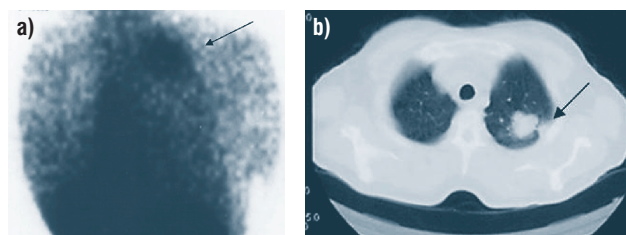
Findings in a patient with squamous cell carcinoma: a) increased uptake of ^{99m}Tc -HMFG1-MoAbs in the left upper lobe (black arrow); b) tumor mass on the CT image in the area of the left upper lobe (arrow).
